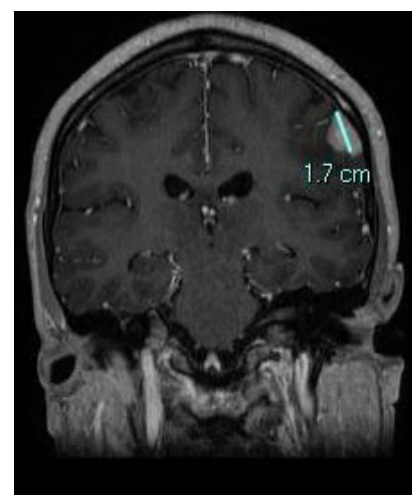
Showing the newly diagnosed B cell lymphoma. Coronal contrasted T1 MRI showing the superficial enhancing mass, found to be B cell lymphoma.
